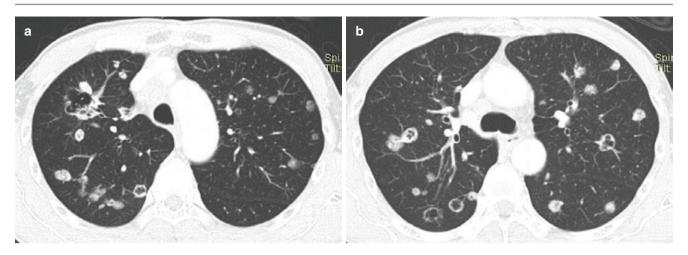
A 60-year-old man with multifocal adenocarcinoma showing cavitations (pseudocavitations). (a, b) Axial CT images show multiple nodules. Biopsy of the largest nodule revealed adenocarcinoma
